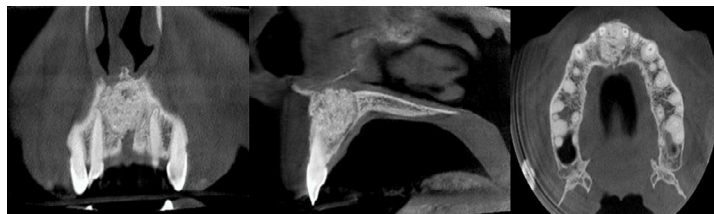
CBCT coronal, sagittal and axial slices of the restored bony defect in the apical frontal region of the maxilla.
